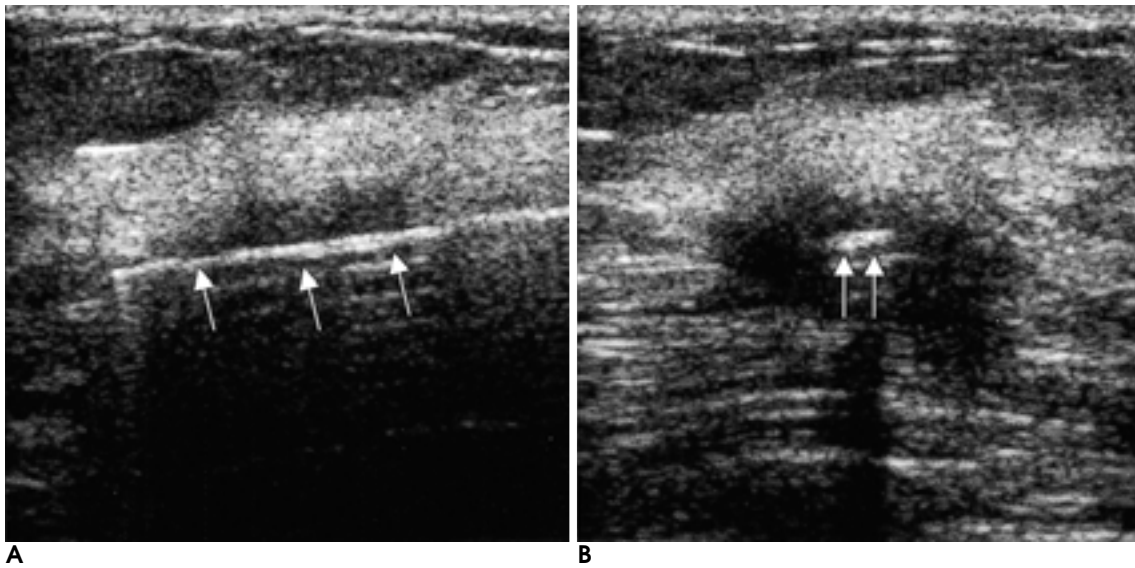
Post-treatment fibrosis in a 27-year-old woman with previous history of invasive ductal carcinoma. Ultrasonography shows an irregular ill-defined hypoechoic mass in the area of previous operation. Transverse (A) and longitudinal (B) ultrasonographic scan shows mammotome needle (arrows) in the mass.
